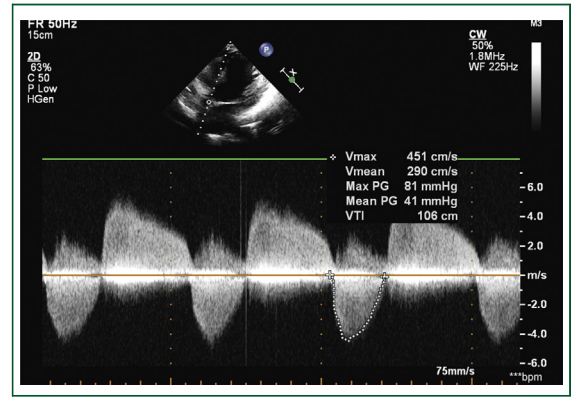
Doppler signal across aortic valve showing maximum and mean gradients of aortic stenosis in a patient with both aortic stenosis and aortic regurgitation.
